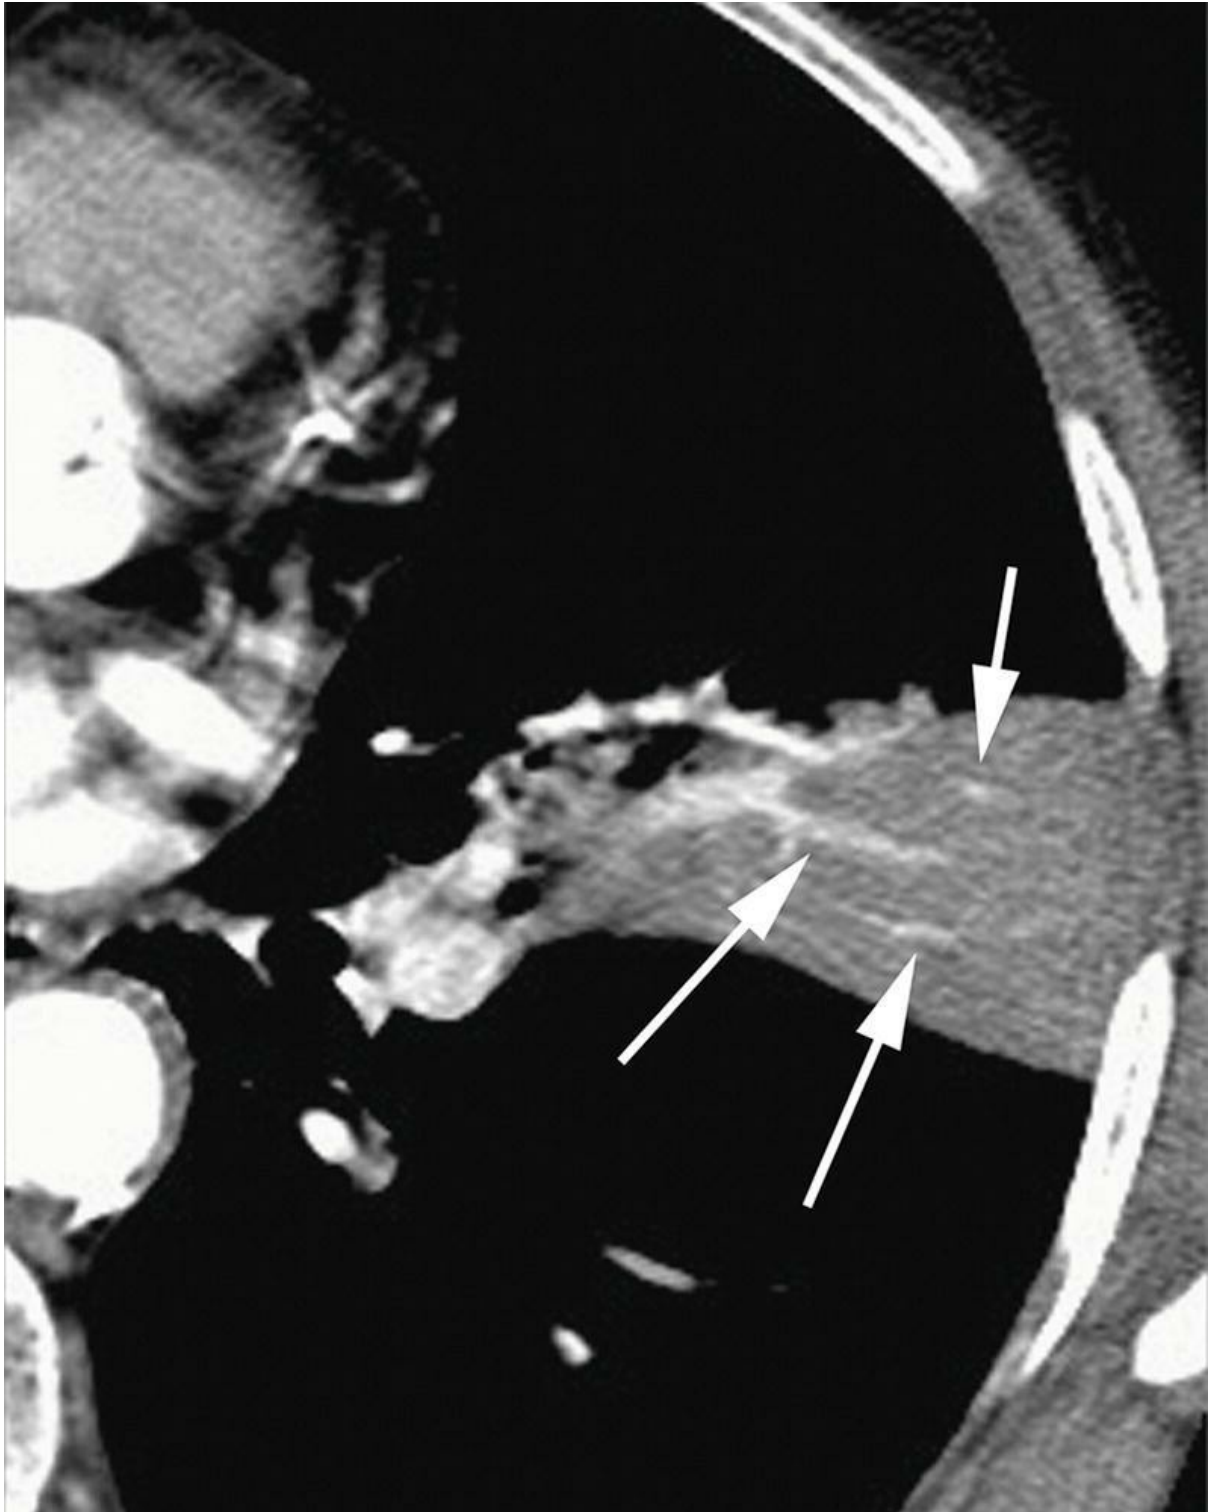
Consolidation: the CT angiogram sign. Contrast-enhanced CT in a patient with pneumonia shows focal consolidation. Opacified arteries (*arrows*) appear denser than does consolidated lung (i.e., the CT angiogram sign). The consolidation borders on the major fissure posteriorly and appears segmental.
